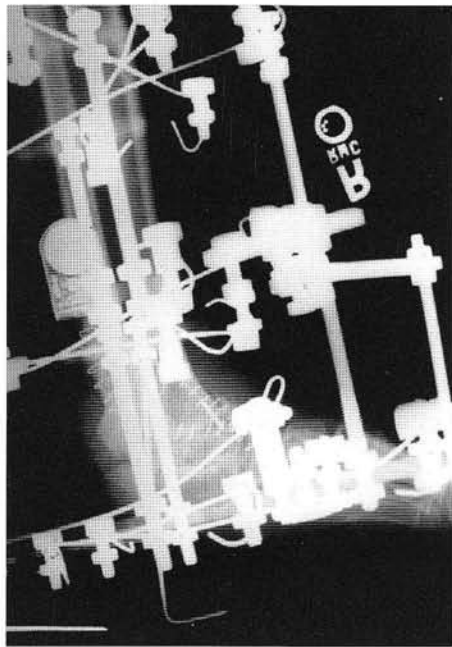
Postoperative radiographic appearance of the tibiocalcaneal arthrodesis with Ilizarov frame.
